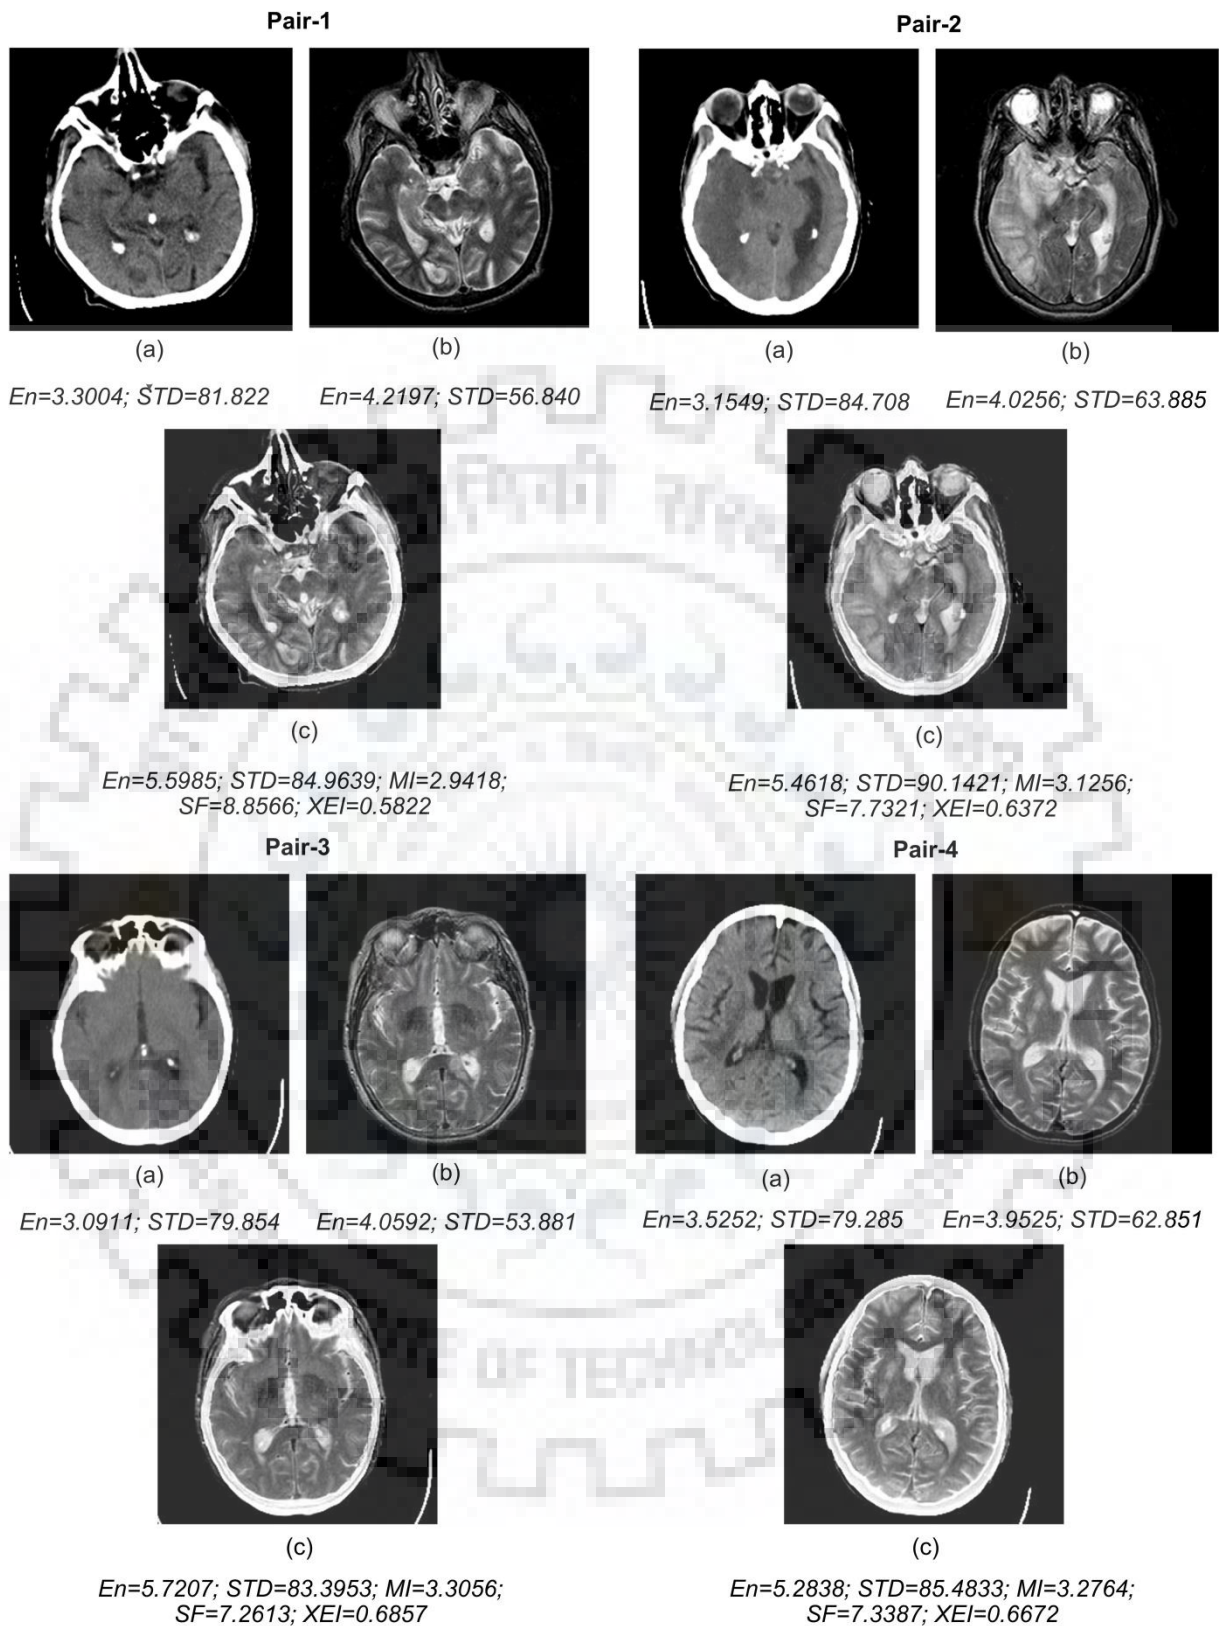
Fusion performance evaluated by the proposed approach on (a) Source CT image (b) Source MR image (c) Fused image
